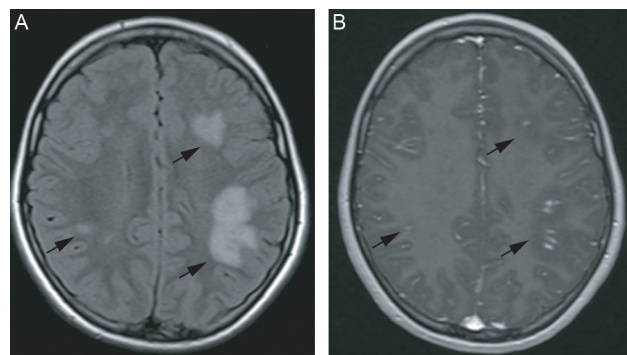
Magnetic resonance imaging patient 2. Turbo inversion recovery magnitude imaging (A) and gadolinium-enhanced imaging (B) of patient 2 upon diagnosis showed several patchy bihemispheric supratentorial signal altered lesions in white matter with gadolinium enhancement. Arrows point to lesions.
